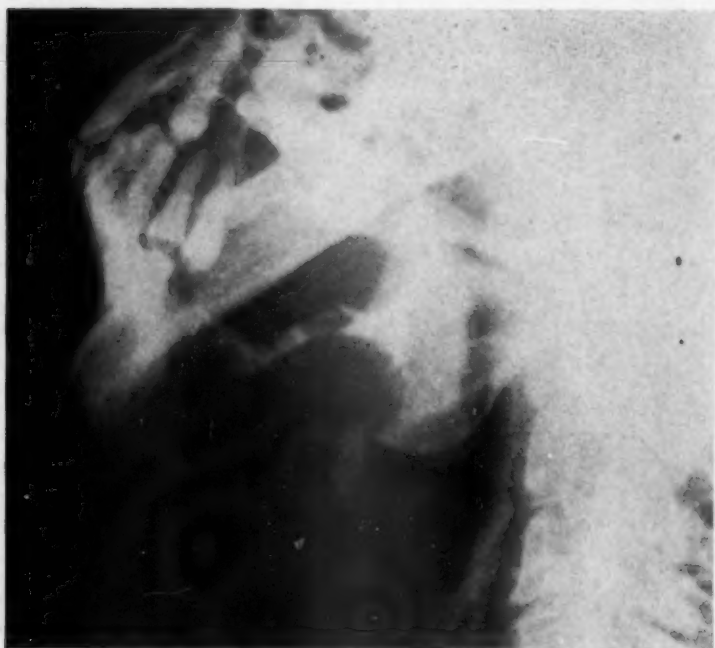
Preoperative x-ray showing extent of osteolytic process with pathologic fracture.
